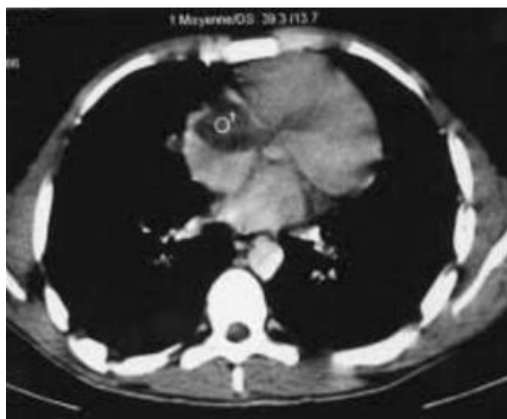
Thoracic CT scan. Cystic formation of 4 cm in diameter in the right atrium
